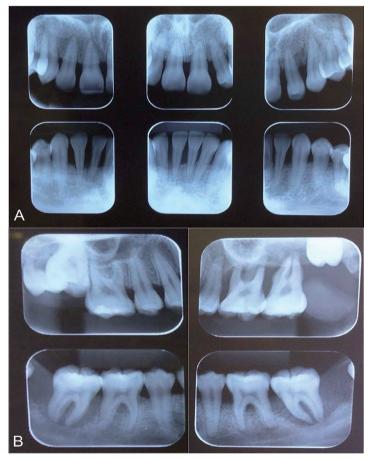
Radiographic aspects. The patient presented moderate to severe teeth mobility that matched on radiographic examination to severe periodontal loss mainly in incisors (A) and molar (B) regions.
